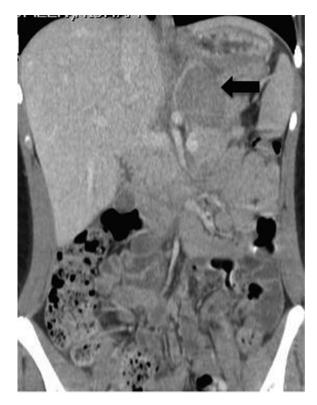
Coronal CT image through mid-abdomen shows an oval mass projecting to the left of the left hepatic lobe.
